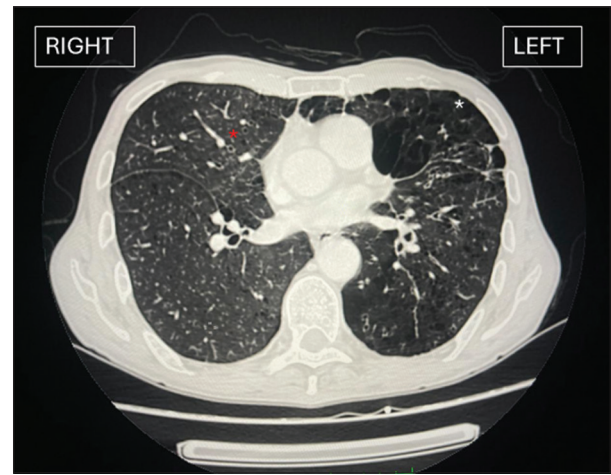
High-resolution computed tomography thorax image showing bilateral hyperinflated lung fields with paraseptal (white asterisk) and centriacinar (red asterisk) emphysematous changes
